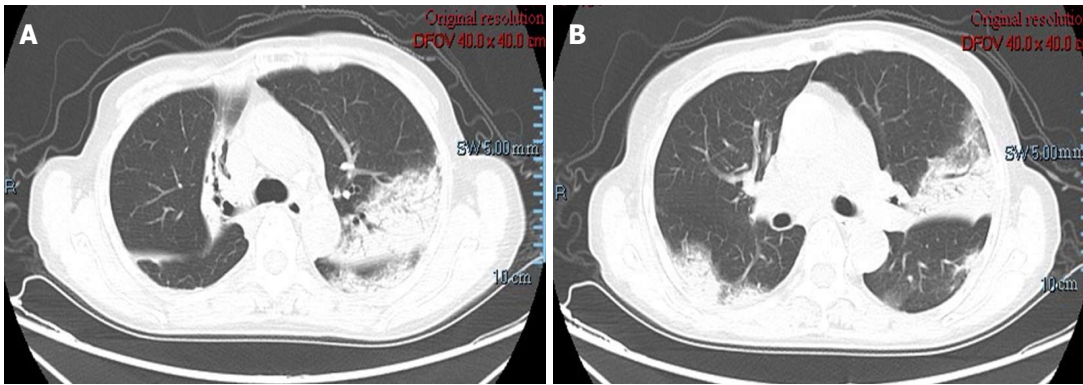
Chest computed tomography scan on admission showed bilateral lesions. The main findings were patchy, consolidation and ground-glass opacities, associated with air bronchogram.
